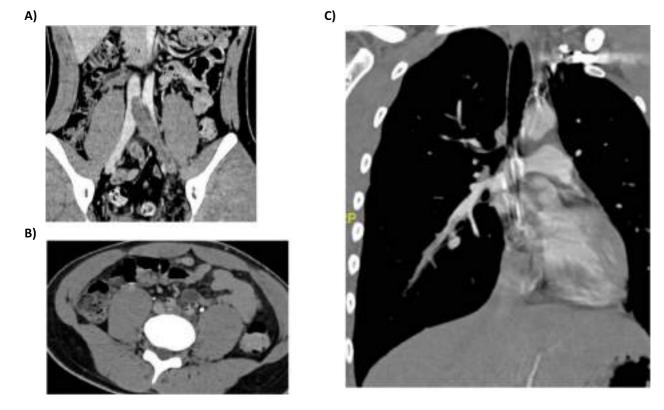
CT angiography findings at diagnosis. (A) Thrombosis in the left iliac vein that appears in the IVC; (B) Thrombosis in the left iliac vein without clear compression syndrome at the crossing behind the right iliac artery; (C) PE in branches of the right basal pyramid artery. Abbreviations: CT, computer tomography; LIV, left iliac vein; RIA, right iliac artery; LIA, left iliac artery; IVC, inferior vena cava; PE, pulmonary embolism.
